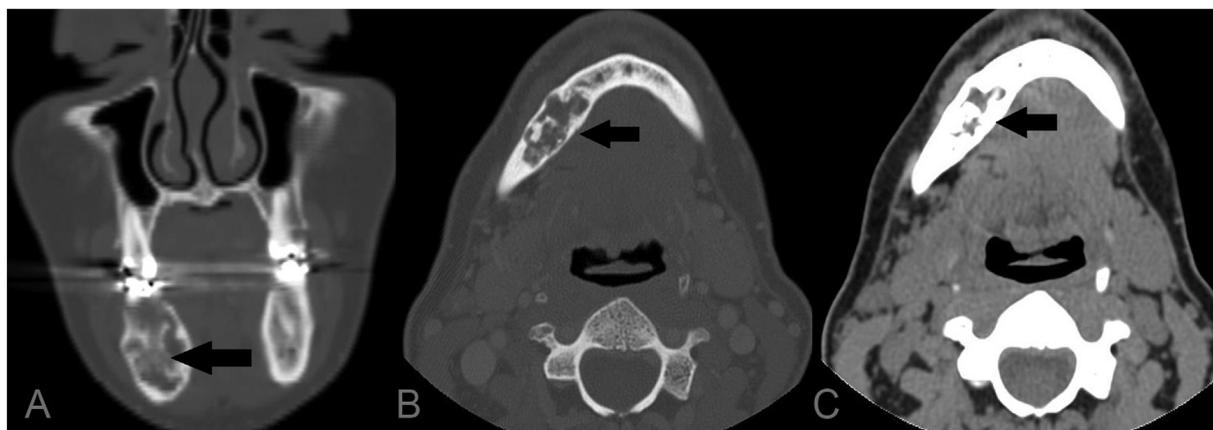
52-Year-old female with tumor induced osteomalacia. (A) Coronal CT (B) transaxial bone window and (C) transaxial soft tissue window reveals a mildly expansile lytic/sclerotic lesion in the mandible on the right. Pathology was consistent with phosphaturic mesenchymal tumor.
